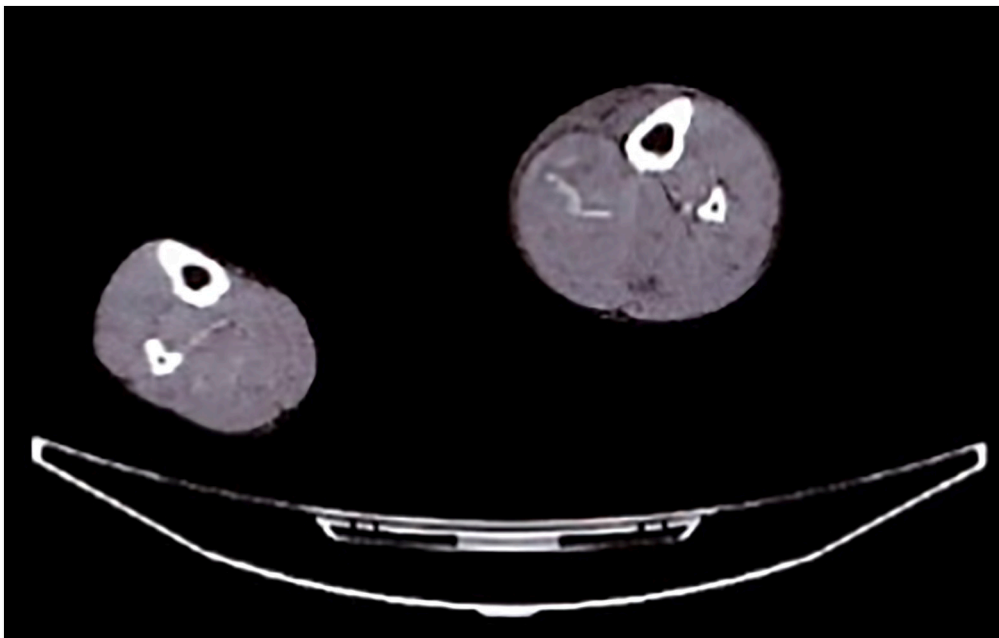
Enhanced computed tomography showing a hematoma originated from the tibial bone tunnel that is compressing the medial calf compartment.
